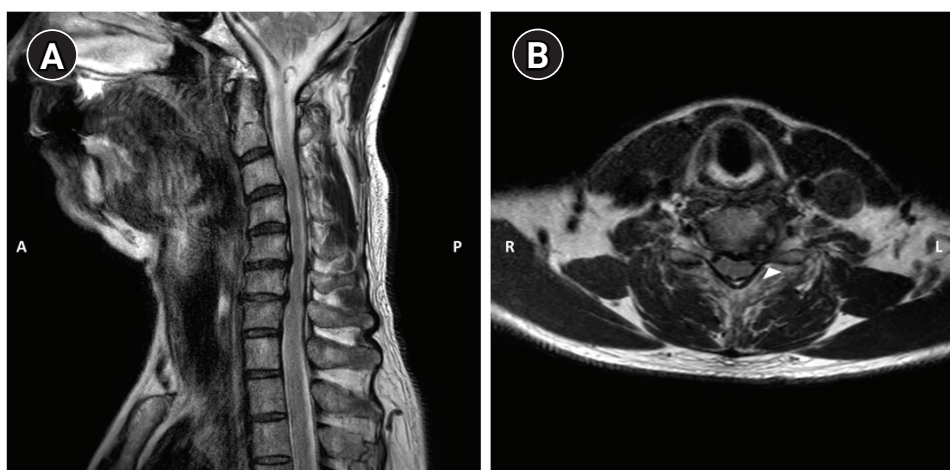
An mDIXON T2-weighted image (A) sagittal view. (B) Axial view. Left foraminal stenosis between the sixth and seventh cervical disks (arrowhead). A: anterior, P: posterior, R: right, L: left.
